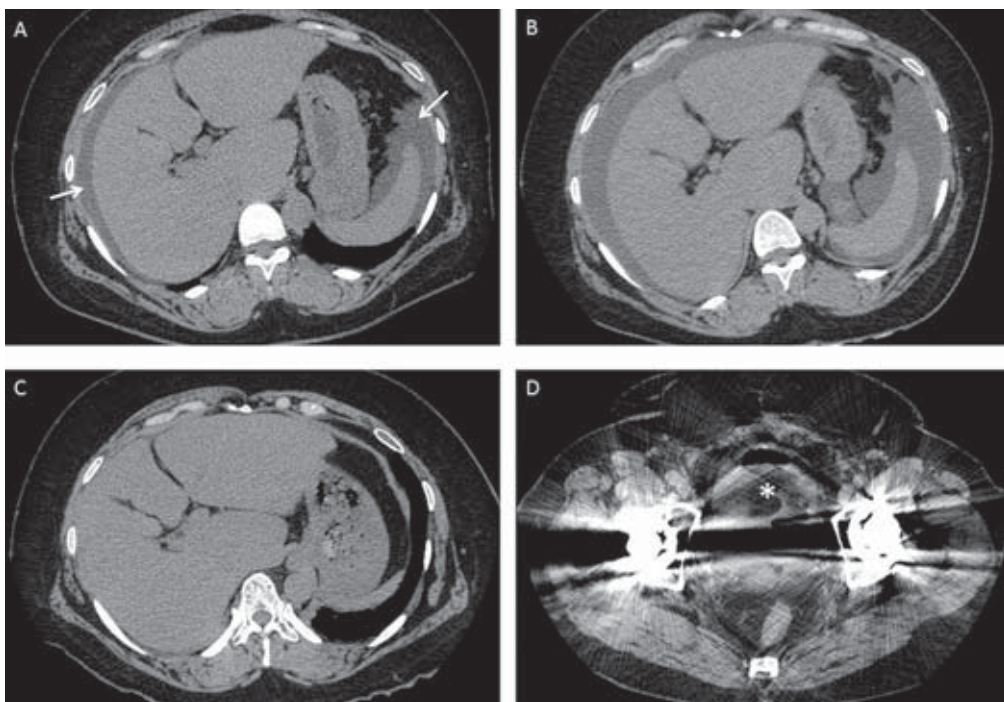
CT of the abdomen
